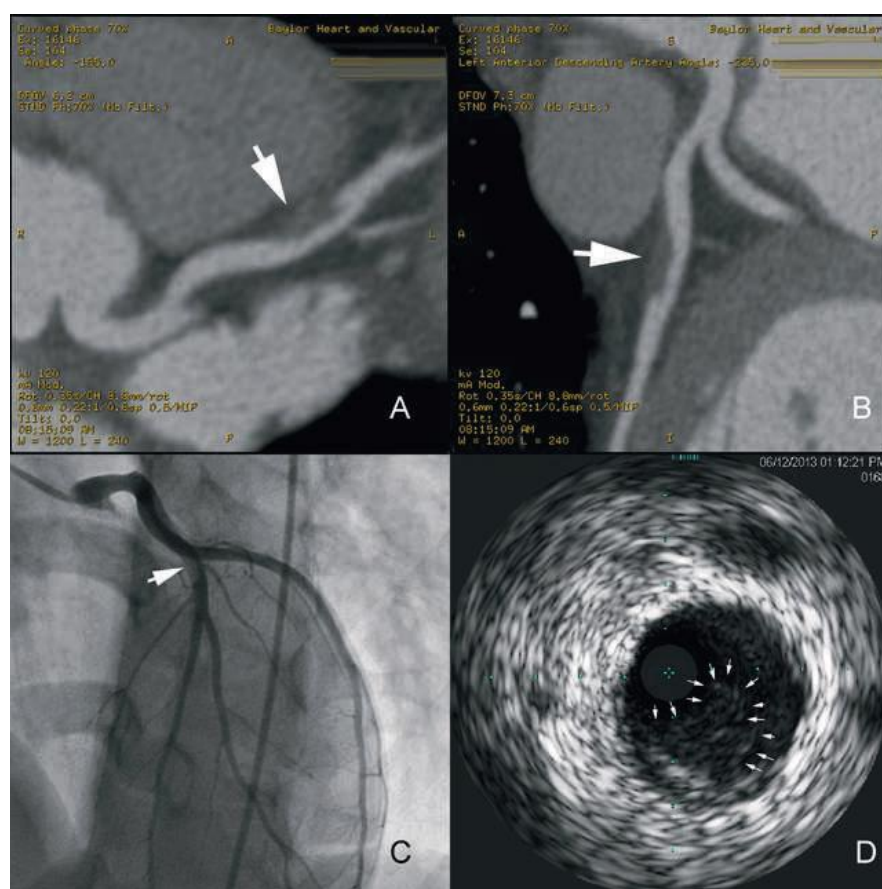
(A, B) Computed tomography coronary angiogram demonstrating an area of decreased density in the proximal LAD concerning for dissection and intramural hematoma (arrows). (C) Coronary angiogram with hazy area in the proximal LAD, concerning for dissection with thrombus (arrow). (D) Intravascular ultrasound confirming a proximal LAD dissection (arrows). LAD, left anterior descending coronary artery.
